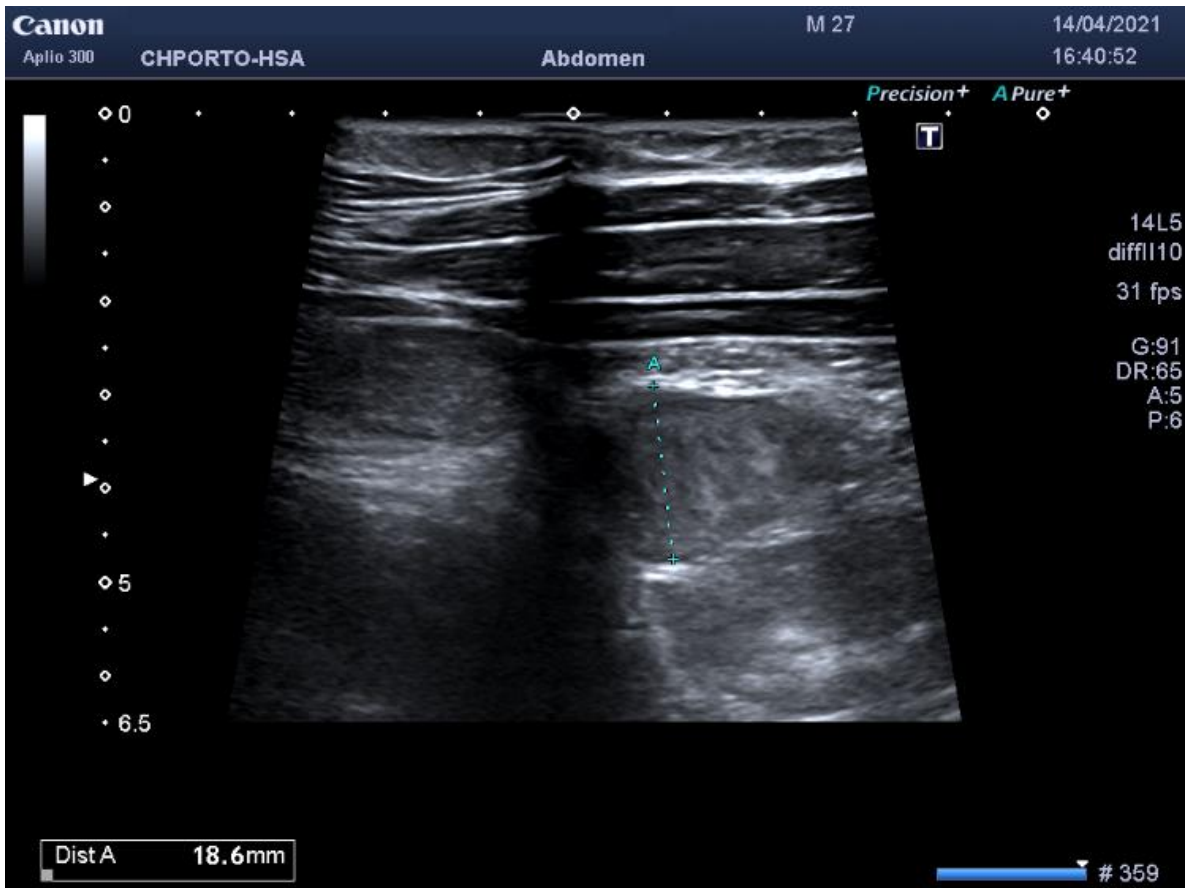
Abdominal ultrasound in the second exacerbation of Ulcerative Colitis from 14/04/2021
